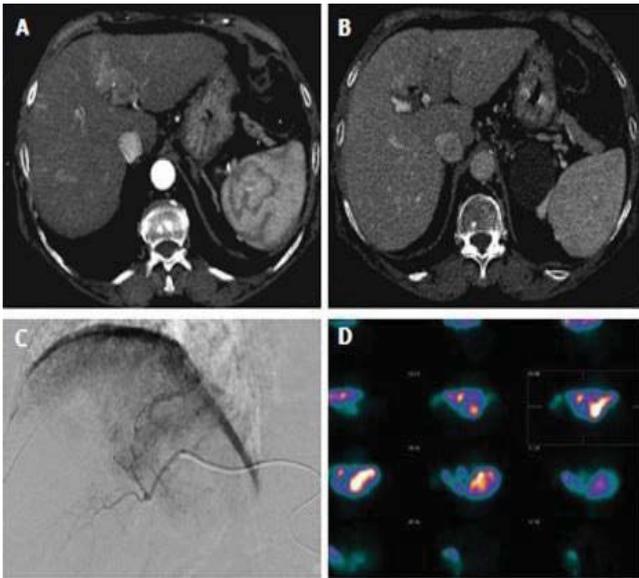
Treatment with Yttrium-90 of infiltrative hepatocellular carcinoma. A and B: The pretreatment computed tomography (CT) showing infiltrative hepatocellular carcinoma in the IV segment; C: The pretreatment angiogram carried out with selective catheterization of the left hepatic artery, arising from the left gastric artery, confirms the hypervascularization of the venous thrombus; D: The pretreatment ^{99m}Tc -MAA single photon emission computed tomography image that reveal the corresponding uptake of MAA by the region of interest [23].
